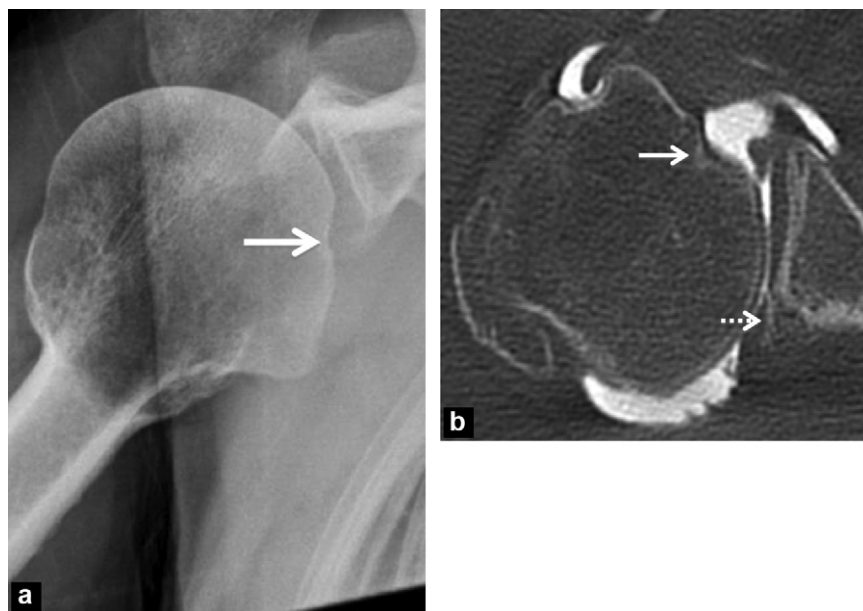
Posterior dislocation of the shoulder. a: the X-ray (Bloom-Obata angle) shows the Mac Laughlin notch (arrow); b: the CT arthrogram also shows a reverse Bankart lesion (dotted arrow).
